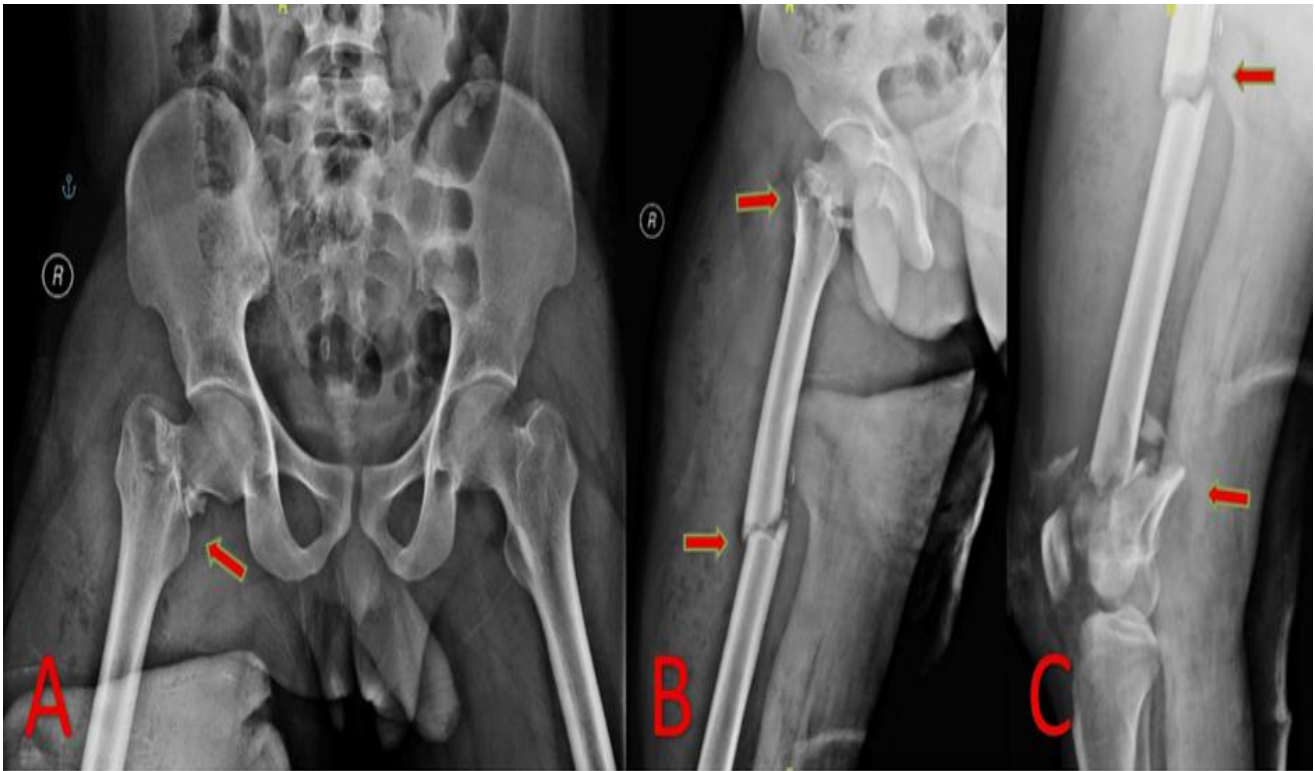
(A-C): Pre-operative radiographs of the right femur in case 4 showing a neck of femur fracture (AO-31B3), femur shaft fracture (AO-32A3), and a distal femur comminuted fracture (AO-33C3.3). (A) Anteroposterior radiograph of pelvis with bilateral hip showing right neck of femur fracture. (B) Lateral view of right proximal thigh showing right neck of femur and shaft of femur fracture. (C) Lateral view of right distal thigh showing right neck of femur and shaft of femur fracture.
